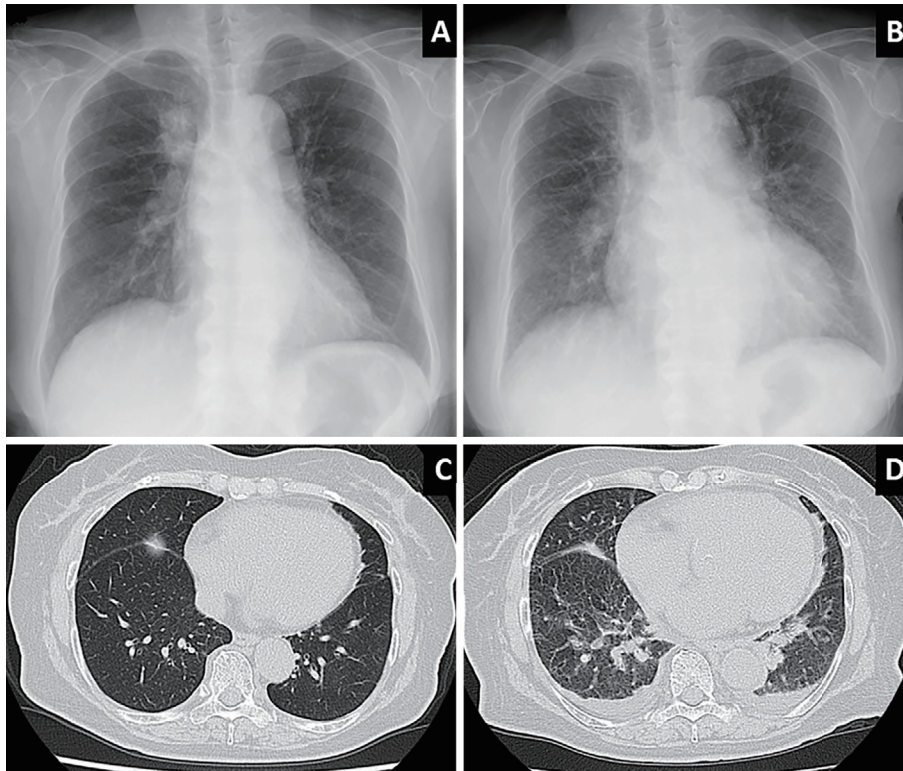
Chest X-ray and computed tomography (CT) findings. Chest X-ray and CT findings before crizotinib therapy (A, C). Cardiac enlargement, bilateral pleural effusion, and pulmonary congestion seen after seven days of treatment with a reduced dose of crizotinib (B, D).
